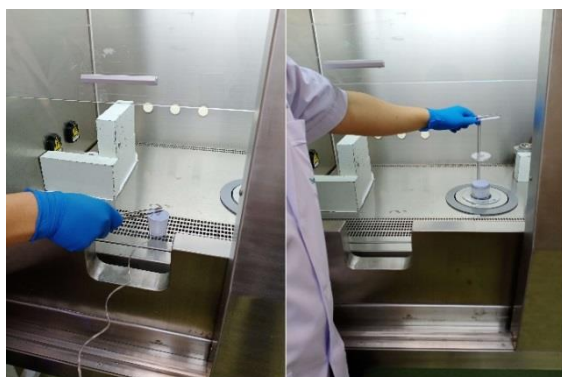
(Left) Shown the injecting output of ^{18}F -FDG from MedRad Intego into a plastic cup (Right) Measurement of ^{18}F -FDG activity in the plastic cup with CRC-55tR dose calibrator.
